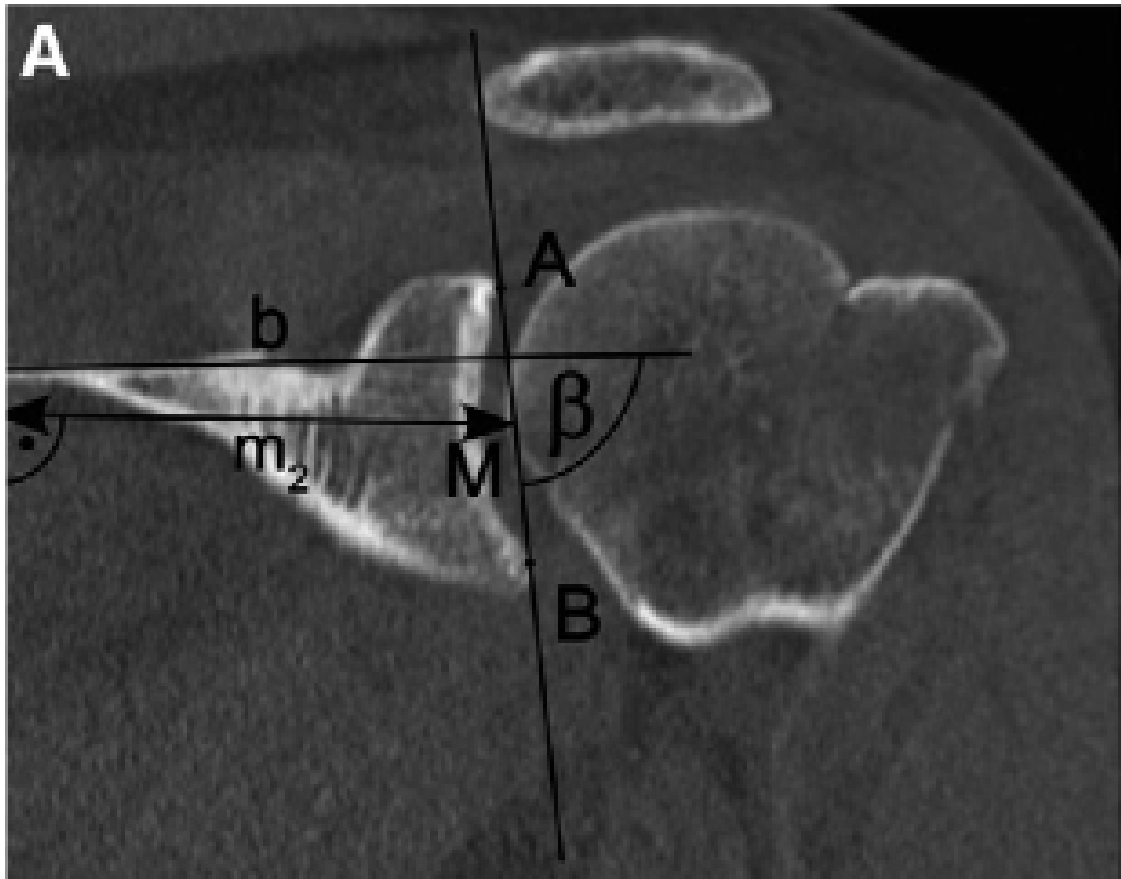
Definition of glenoid inclination angles on CT scans
